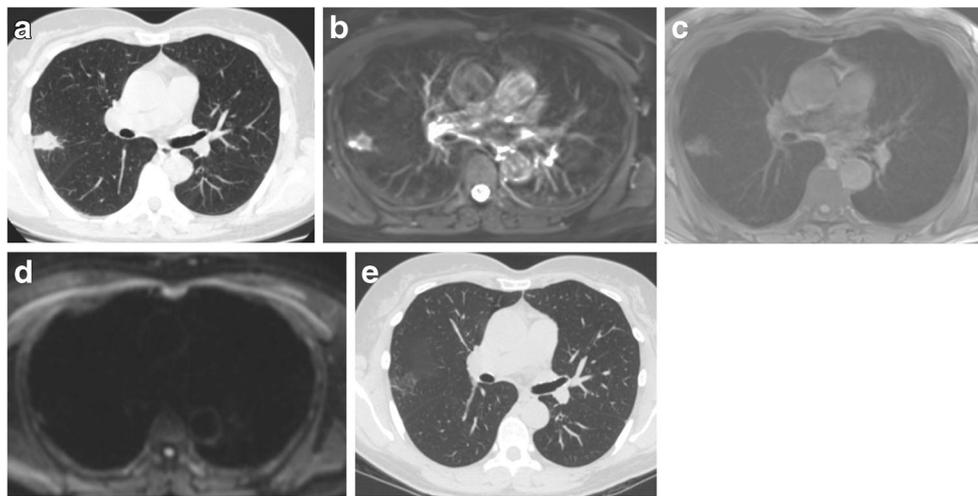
Images from a 59-year-old asymptomatic male smoker. a CT demonstrated the presence of a spiculated solid pulmonary nodule with a diameter of 2.4 cm in the right upper lobe. b A T2-weighted sequence showed hypointense signal in the nodule. c A T1-weighted sequence showed hyperintense signal in the nodule. d A diffusion-weighted
